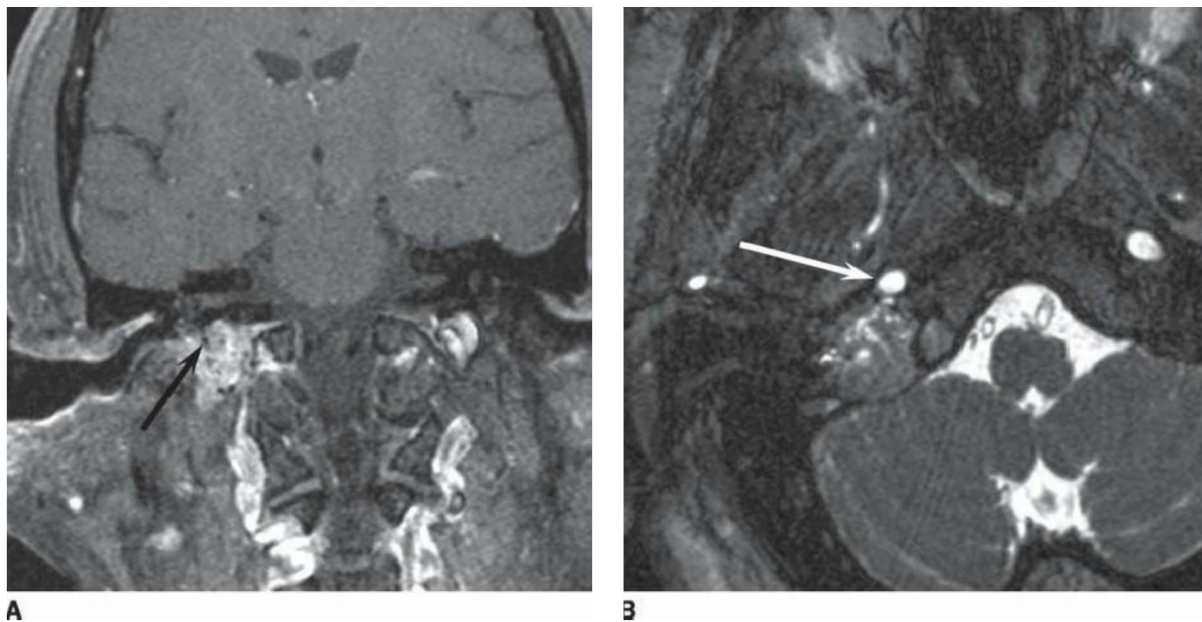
Jugular paraganglioma. A: Coronal enhanced fat-suppressed T1-weighted image shows avid enhancement with focal round flow voids (*arrow*) indicating large feeding vessels. B: Axial fat-suppressed T2-weighted image demonstrates the proximity of the tumor to the vertical portion of the petrous internal carotid artery (*arrow*) as well as the intracranial but extradural component of the tumor in the jugular foramen posteriorly.
